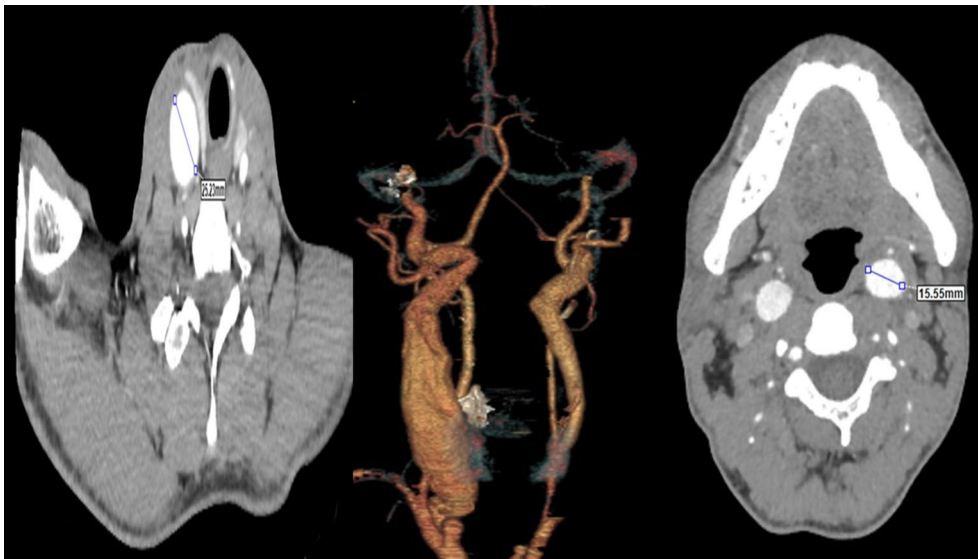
Aneurysm (2.5 cm) in the right CCA and aneurysm (1.5 cm) in the left CCA in computed tomography angiography.
